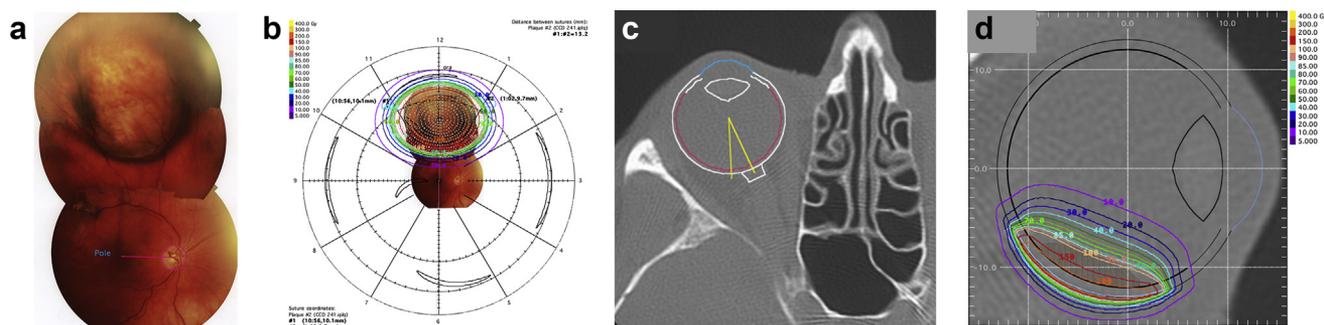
Eye Physics treatment methodology. (a) fundus photograph of melanoma, (b) fundus photograph over a fundus landmark map with isodose profiles, (c) orbital CT of affected eye, (d) radiation profile mapped over CT image. CT = computed tomography.
